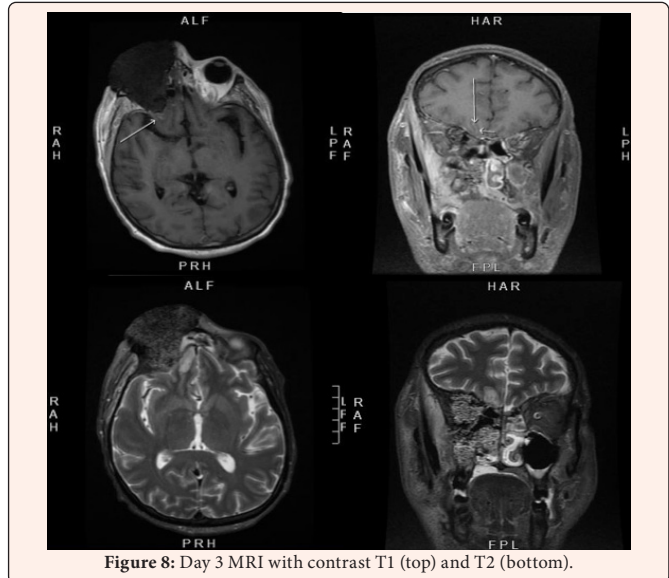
Day 3 MRI with contrast T1 (top) and T2 (bottom).
